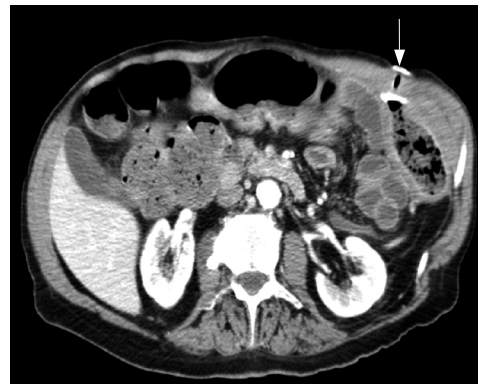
CT-scan showing the colostomy tube in place (arrow) and a normal-appearing colon.
